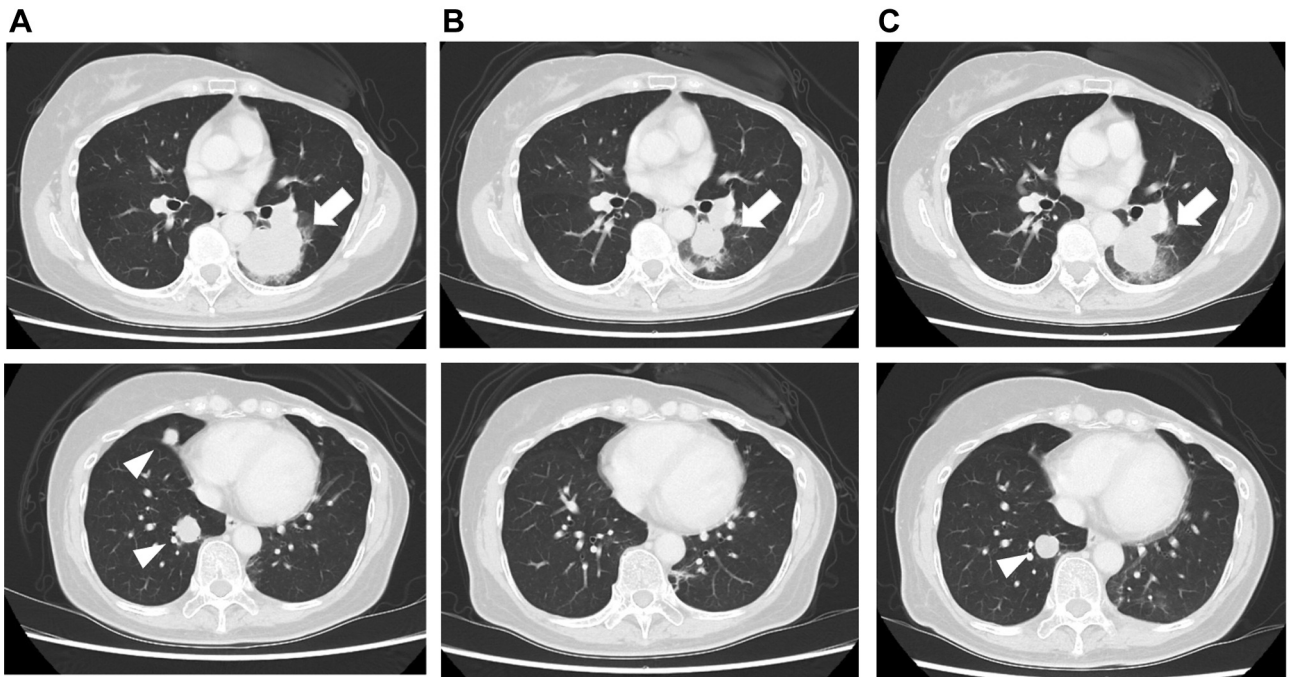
Computed tomography imaging during treatment with atezolizumab and nab-paclitaxel. A) Before treatment, the presence of multiple lung metastases (white arrowheads) was observed and the largest lesion measured 45×38 mm in the left lung (white arrows). B) After 3 months of treatment, the tumor shrank (white arrows). C) After 6 months of treatment, tumor regrowth was observed (white arrows and arrowheads).
